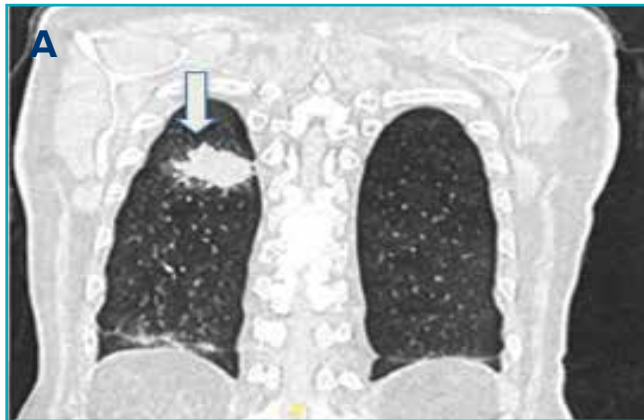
High-resolution computed tomography (HRCT) images — coronal, axial (A and B), and sagittal (C) views — showing a spiculated soft-tissue mass in the superior segment of the right lower lobe, with background centrilobular emphysema (white arrows).
